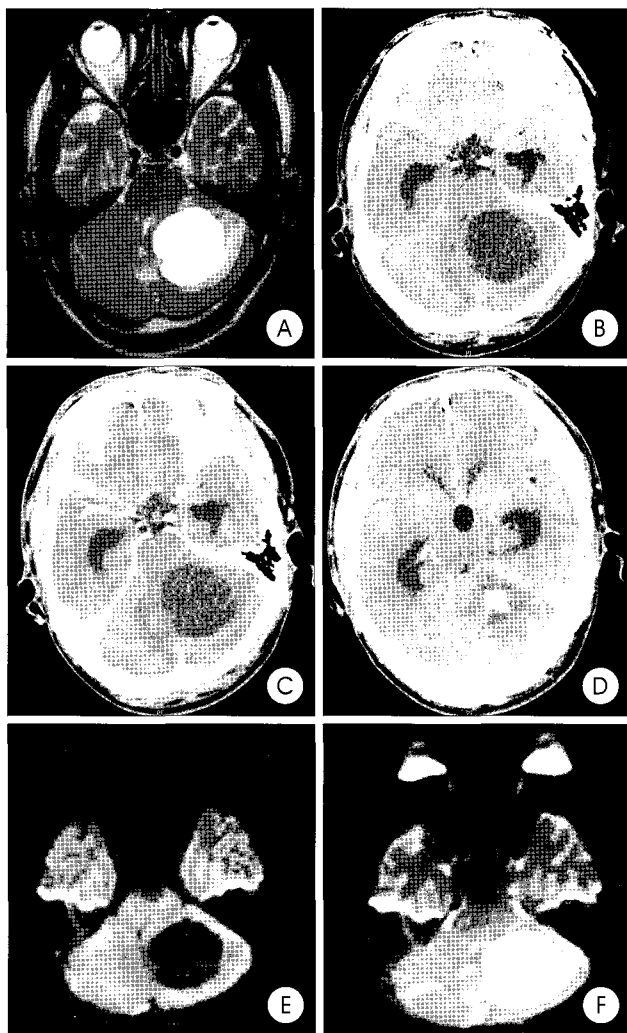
Hemangioblastoma is observed in left cerebellar hemisphere. It is high signal intensity on T2WI (A) and low density on computed tomography (B, C). Focal enhanced lesion is also seen (D). Similar to the above mentioned brain tumors, low signal intensity on DWI (E) and high signal intensity on apparent diffusion coefficient mapping (F).
